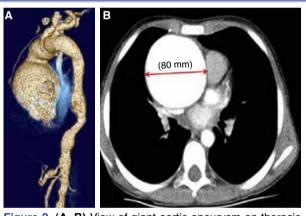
(A, B) View of giant aortic aneurysm on thoracic computed tomography scan.
